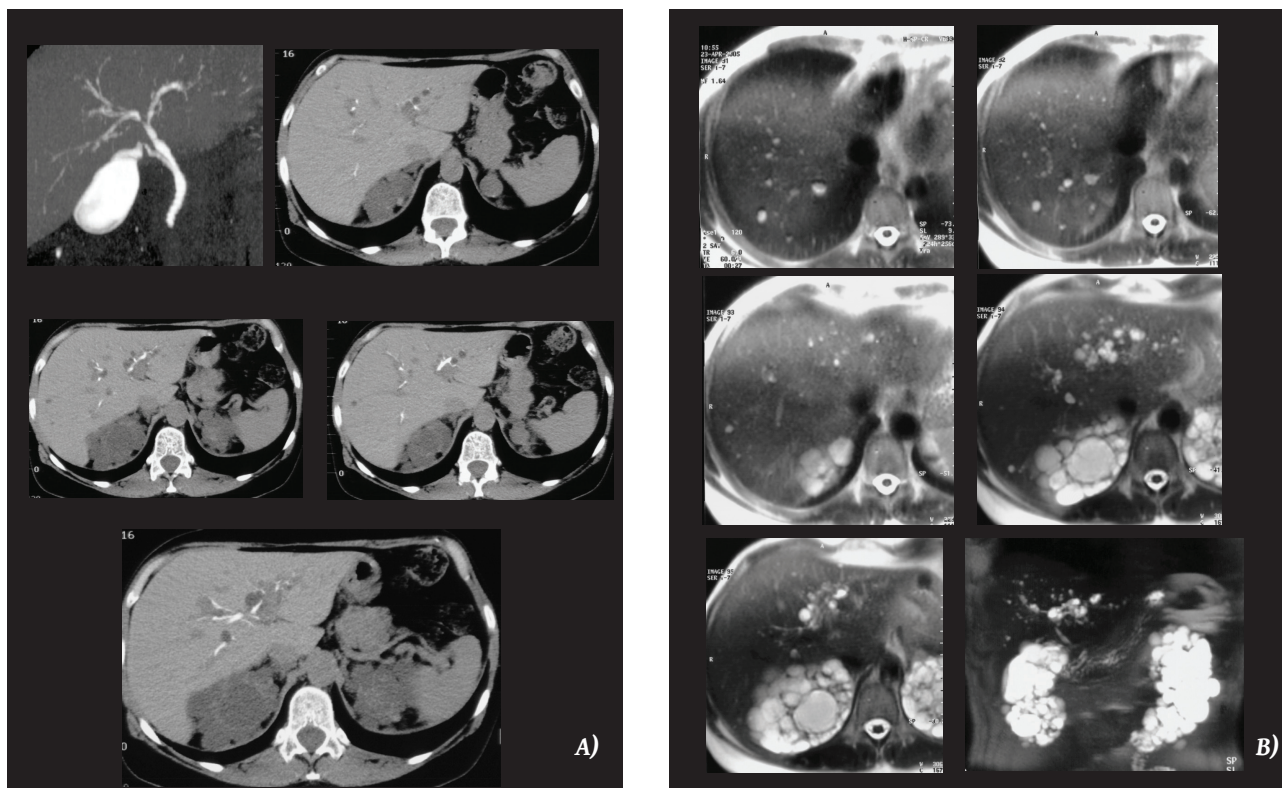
Intrahepatic peribiliary cysts, non-parasitic simple cysts, and Von Meyenburg complex lesions in a patient with ADPKD. a) CT Cholangiography and axial source images, which reveal the normal biliary tree, peribiliary cysts, simple cysts, and polycystic kidney disease. b) MRCP and MR T2WI axial images, which more clearly depict a normal biliary tree, peribiliary cysts, simple non-parasitic cysts, lesions of Von Meyenburg, and polycystic kidney disease.
